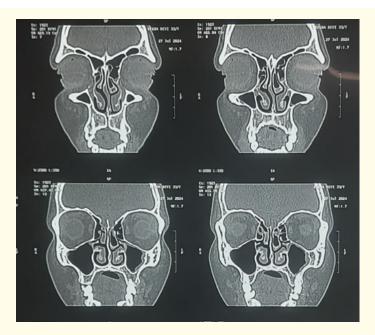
Pre-Operative Computed Tomography of patient showing concha bullosa (left).
